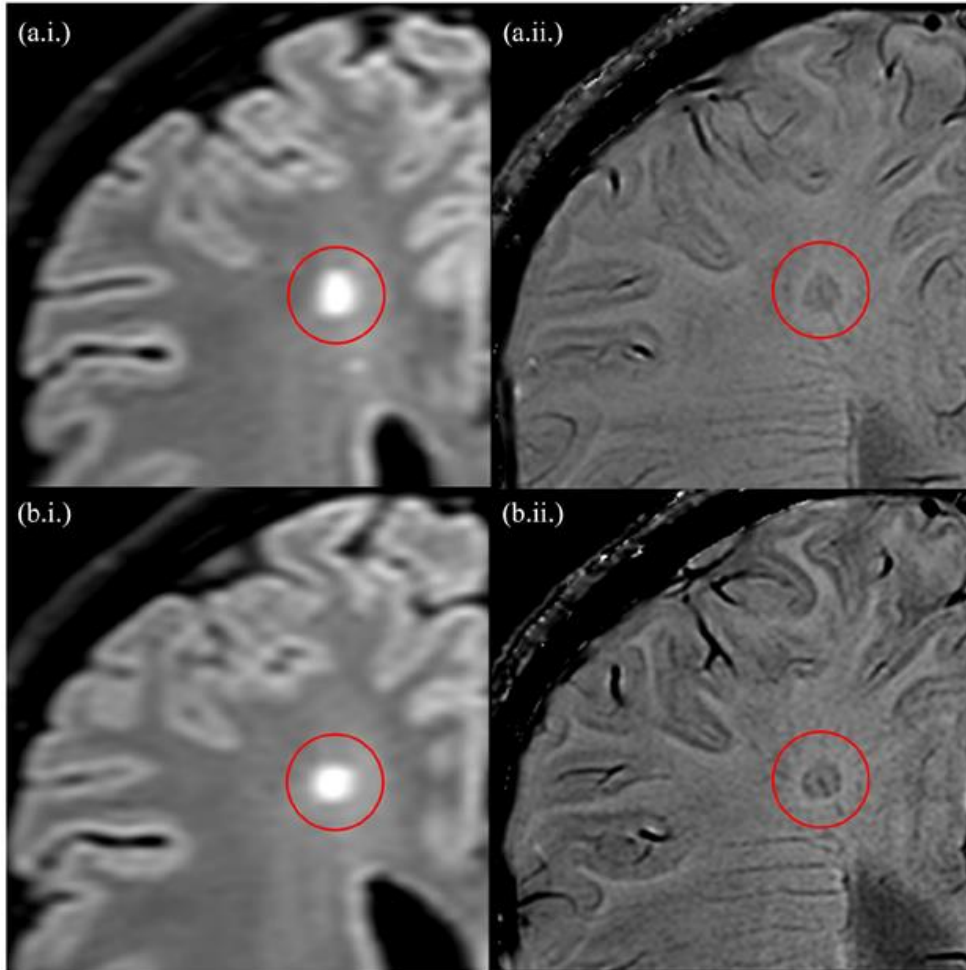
Consecutive slices of a Paramagnetic Rim Lesion (with a central vein) detected using the fluid-attenuated inversion recovery (a.i and b.i) and phase-sensitive imaging (a. ii. and b.ii.), at 3T MRI. As per the study protocol, the lesions demonstrate a hypointense, ring-like structure corresponding to the lesion edge which is present on at least two consecutive slices.
